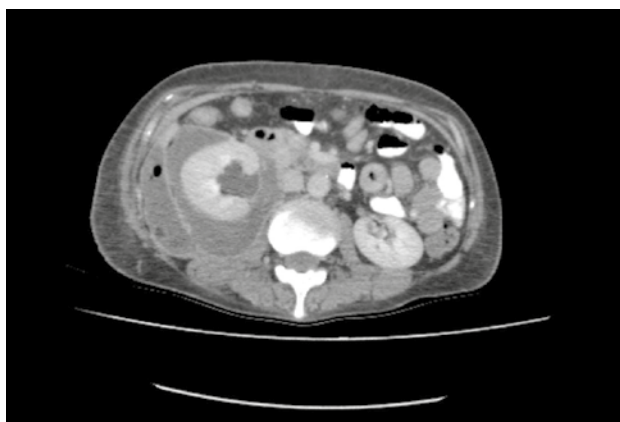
Contrast-enhanced CT image. Axial image of the abdomen.
